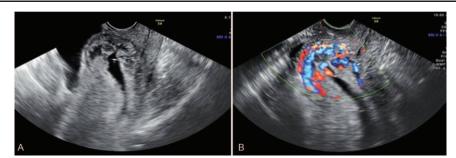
Ultrasound reveals an obvious enlargement of the previous cesarean section cicatrix and found a mixed mass attached to the cicatrice with a very thin myometrium (A). Color Doppler ultrasonic displays a mixed mass surrounded by the abundant color bloodflow signal (B).
